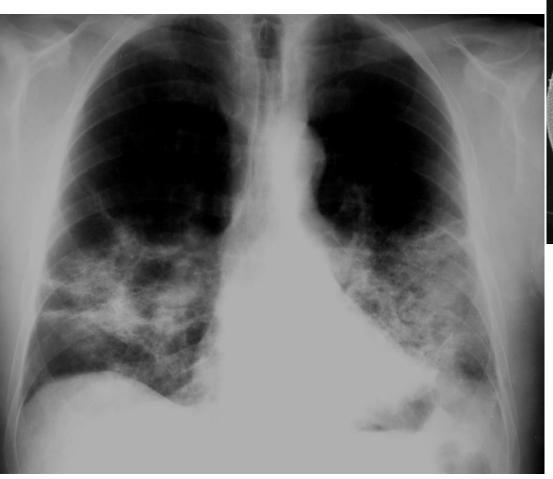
Case 1. Chest roentgenogram shows minimal interstitial infiltrates (left). Gallium scan shows marked diffuse uptake in lungs (right).
